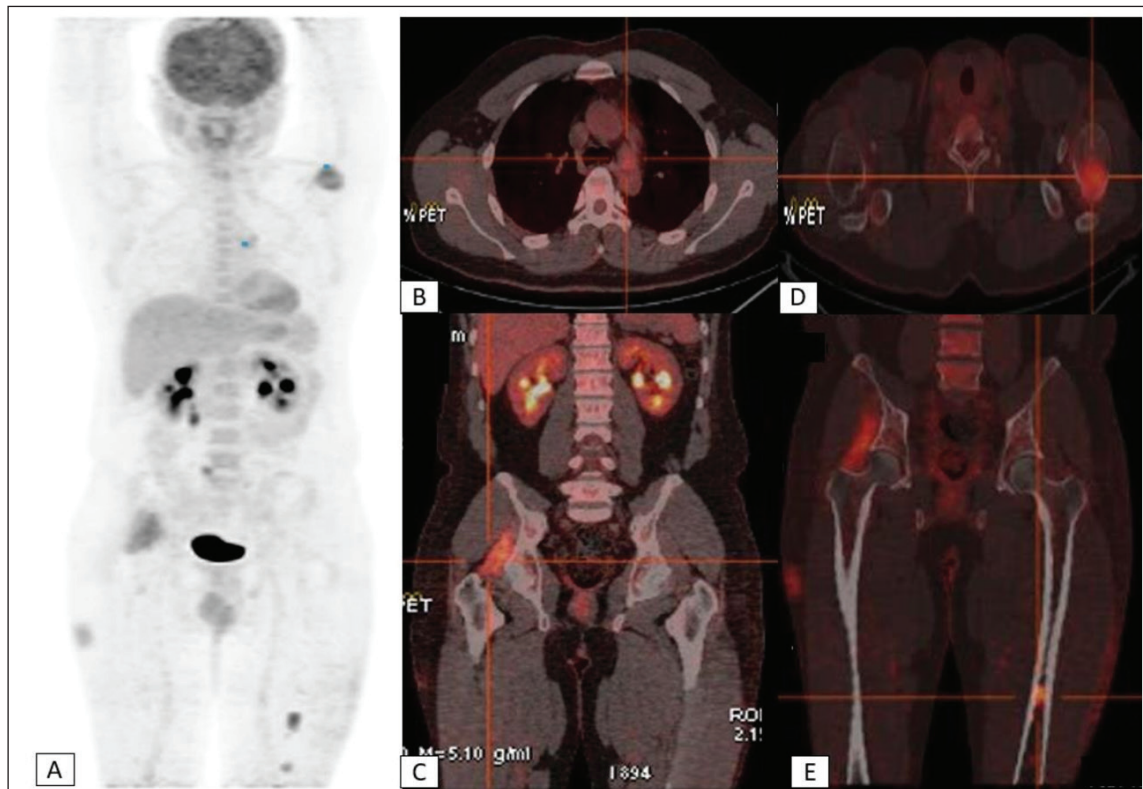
(A): Maximum intensity projection (MIP) from the ^{18}F -FDG PET-CT scan displays both the physiological and pathological distribution of the radiopharmaceutical throughout the entire body, providing a comprehensive overview of metabolic activity. (B): The axial fusion image highlights a slightly hypermetabolic mediastinal lymph node located in the aortopulmonary window, suggesting pathological involvement. (C): The coronal fusion image demonstrates hypermetabolism in the right gluteus minimus muscle, indicating abnormal metabolic activity in this region. (D) and (E): Axial and coronal fusion images reveal pathological hypermetabolic bone foci in the left humeral head and left femoral diaphysis, indicative of a mixed and atypical presentation of Rosai-Dorfman disease.
